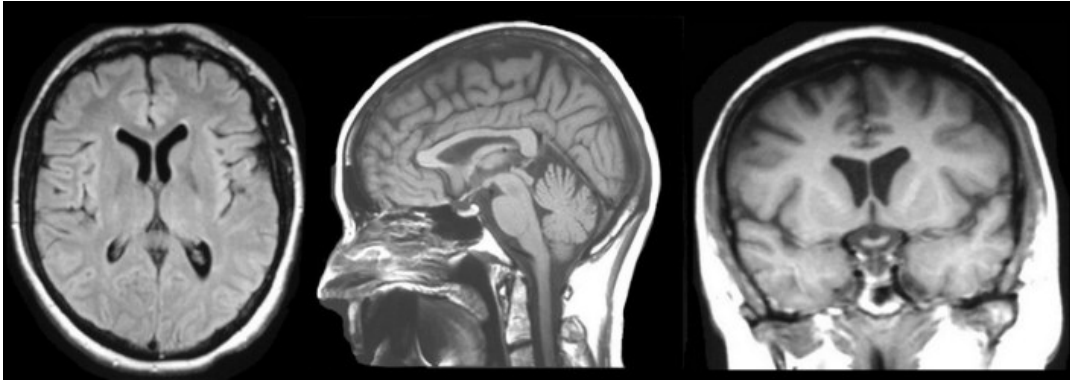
MRI images of a brain in all three planes: axial, sagittal and coronal (Cole et al., 2018)
